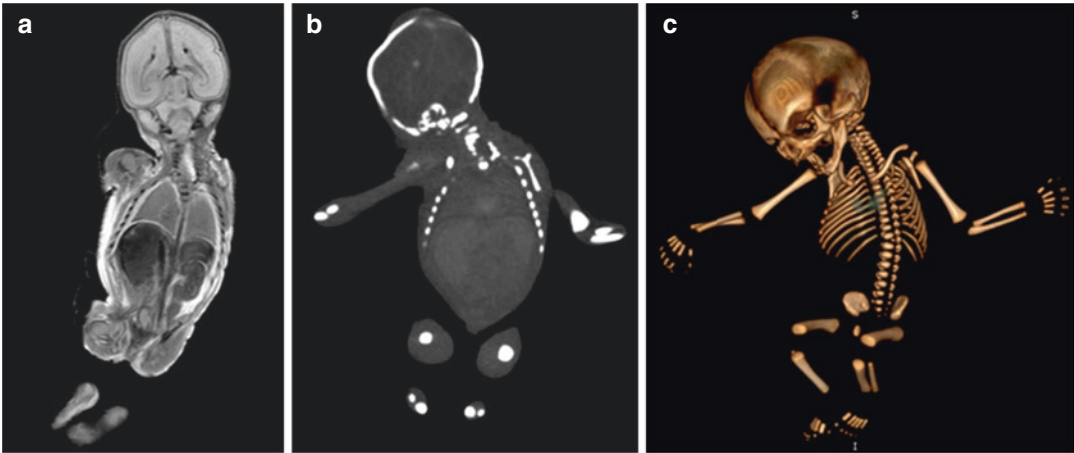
Comparison of post-mortem MRI (a) and post-mortem CT (b) of a 20-week-old foetus. Visceral organs are not clearly seen on post-mortem CT, whilst the bony skeleton is clearly displayed on reconstruction of the CT image (c)
